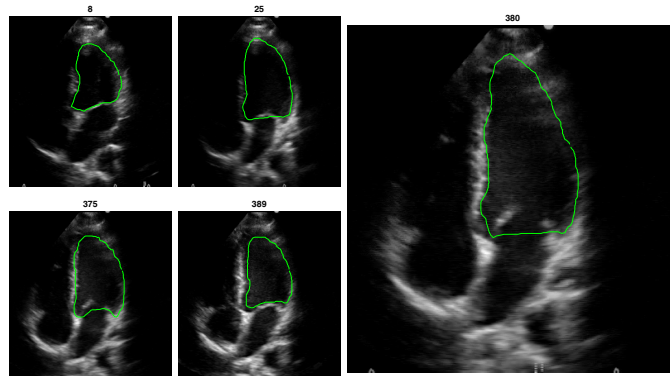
Sample frames from one ultrasound video sequence with frame number on top.
